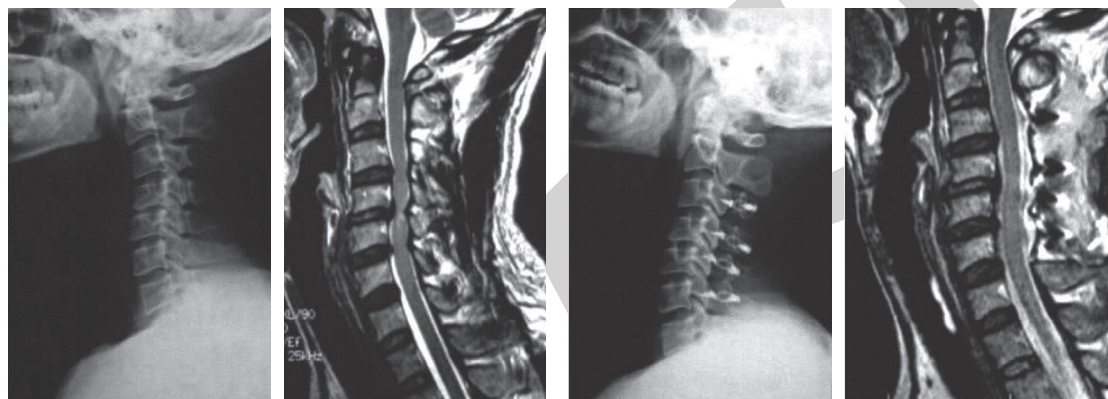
Comparison of preoperative and postoperative MRI and X-ray in posterior laminoplasty (LMP) surgery.
